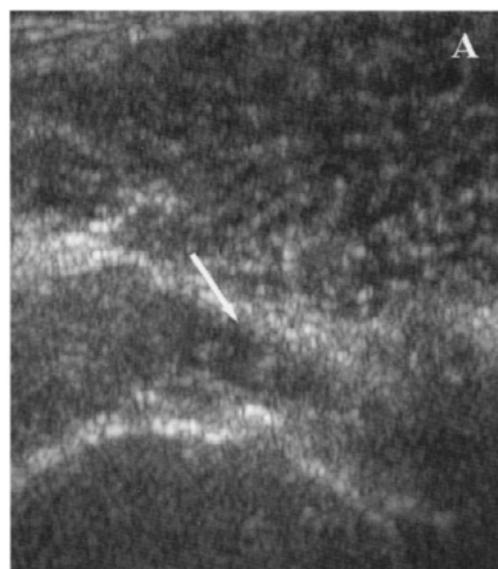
Transverse images of the supraspinatus tendon. A) Conventional ultrasound shows a small full thickness tear on the front side edge of the tendon (arrow); B) Real Time Compound Imaging shows a remarkable increase in lesion conspicuousness and the broken tendon fibres as well (arrow). The cartilage surface is better displayed (arrowhead).
